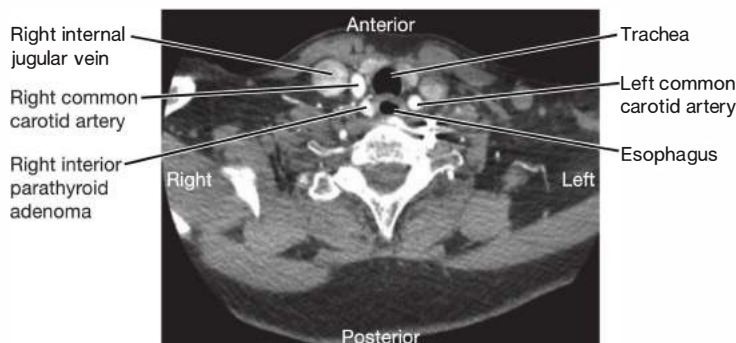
• Parathyroid CT demonstrates a contrast-enhancing lesion posterior to the right common carotid artery, posterolateral to the trachea, and lateral to the esophagus, representing a right inferior parathyroid adenoma.
